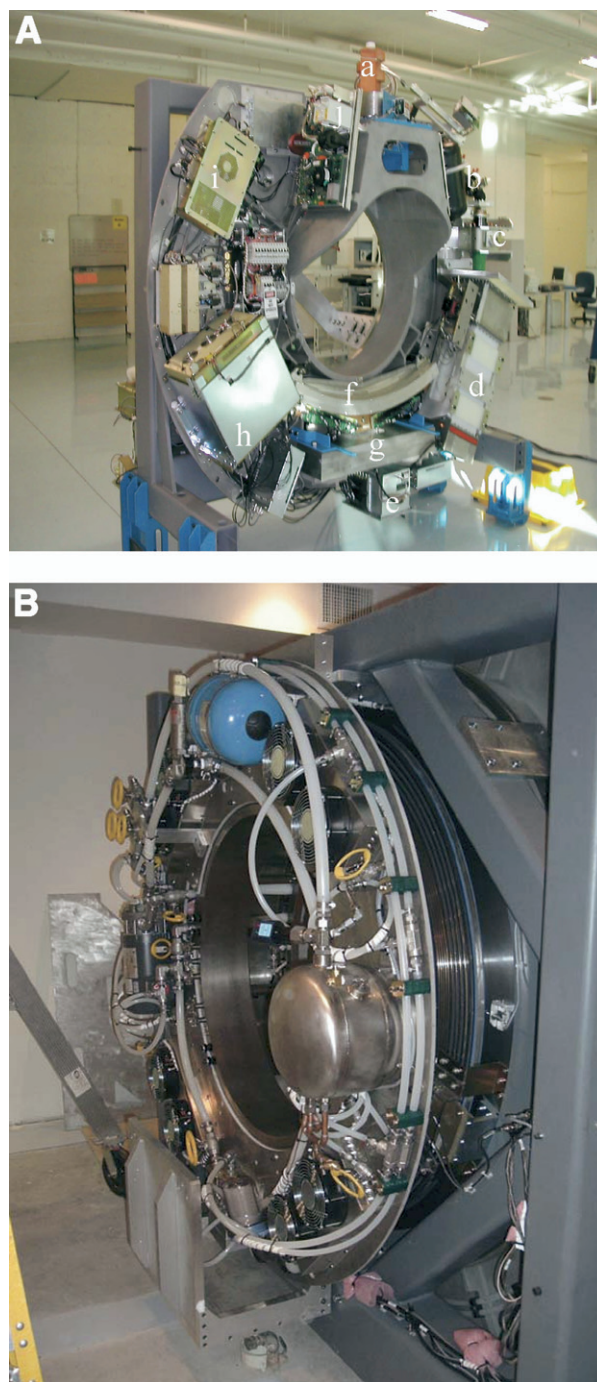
(A) Front side of gantry showing various subsystems including (a) linac, (b) circulator, (c) magnetron, (d) pulse forming network, (e) image data acquisition system, (f) CT detector, (g) beam stop, (h) high voltage power supply, (i) control computer, and (j) gun. Image courtesy of TomoTherapy, Inc. (B) Backside of gantry showing cooling system.
